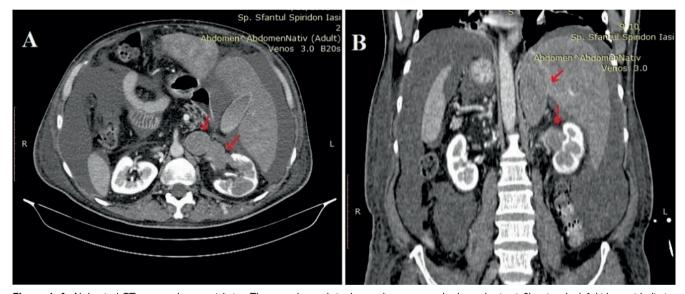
A. Abdominal CT venous phase - axial view. The mass descends in the renal segment, on both renal veins, infiltrating the left kidney with diminished peripheral renal parenchyma preserved. B. Abdominal and pelvic CT venous phase - coronal view. Tumor indicated by the red arrows. Appearance of an infiltrated subcutaneous adipose tissue at the abdominal wall and both thighs.
